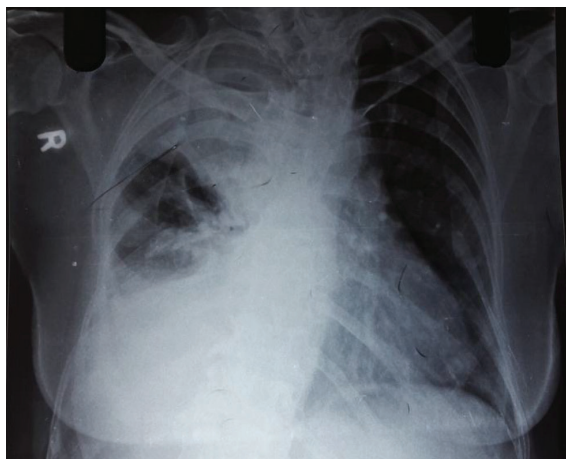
X-ray chest done s/o right upper zone consolidation with right sided pleural effusion with cardiomegaly
